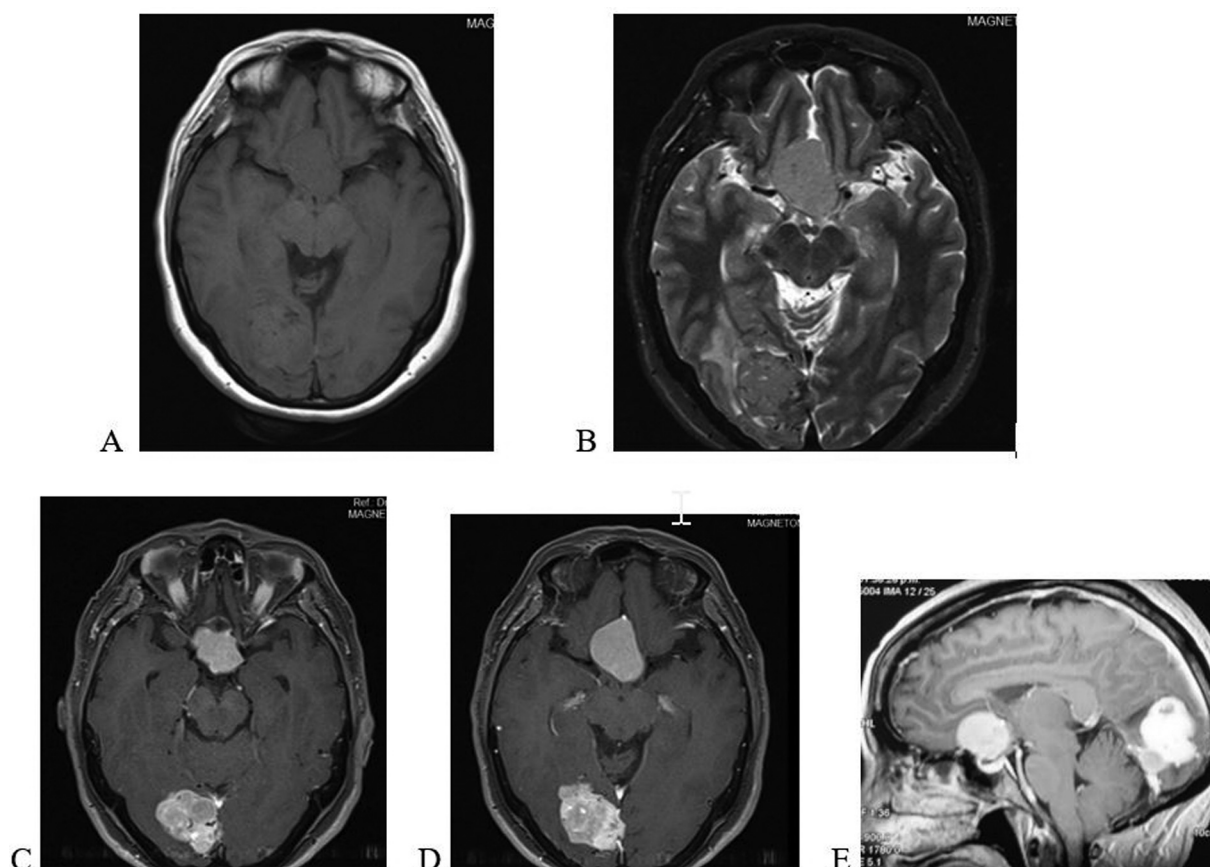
The magnetic resonance imaging (MRI) of both brain tumors are isointense on T1 (A) and T2 (B) sequences; T1-weighted MRI exhibiting strong enhancement of the two brain tumors following gadolinium administration (C, D, and E).
